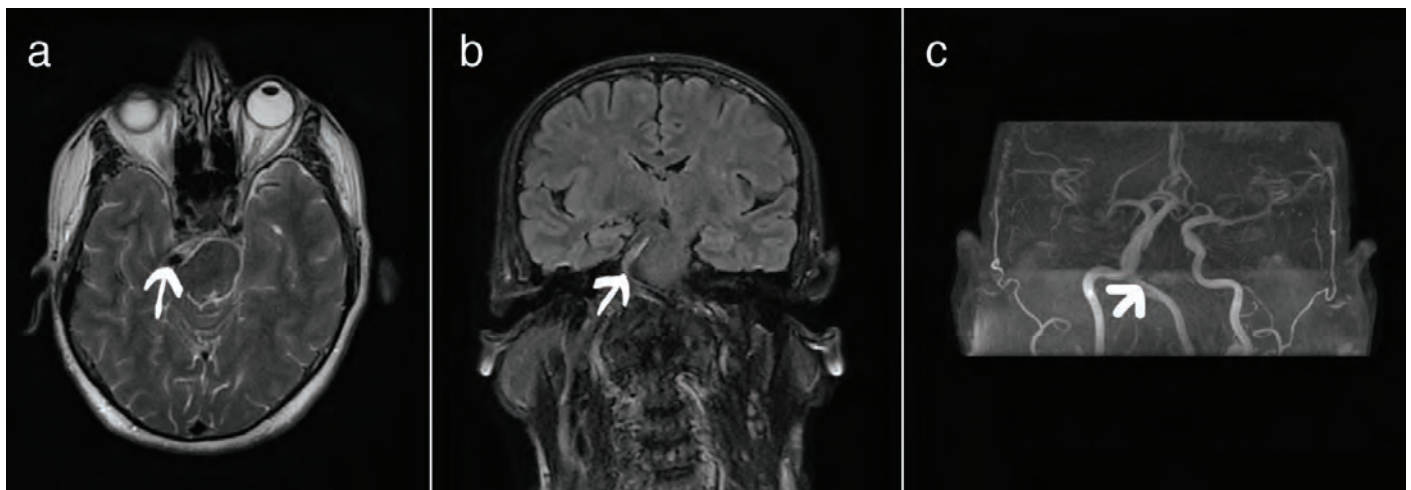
T1 axial magnetic resonance imaging shows a marked enlargement of the basilar artery and compression of pons (a). Widened basilar artery (b). MR angiography delineates the left vertebral artery as well as elongated and tortuous basilar artery (c)
